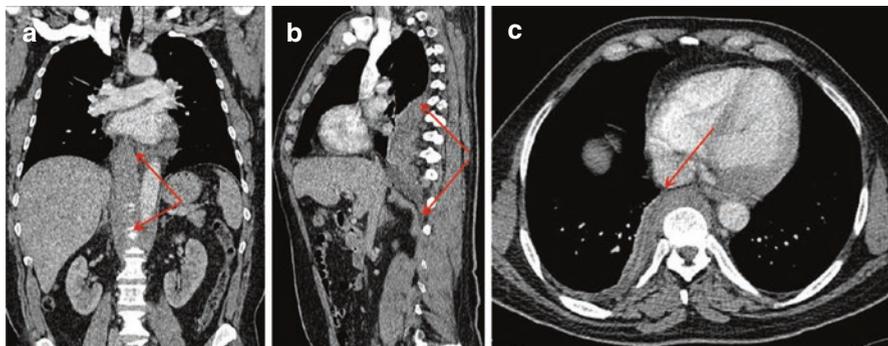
Coronal (a), sagittal (b), and axial (c) views of contrast-enhanced CT scans of the chest showing mediastinal fibrosis from D4 to D12 (red arrows)
